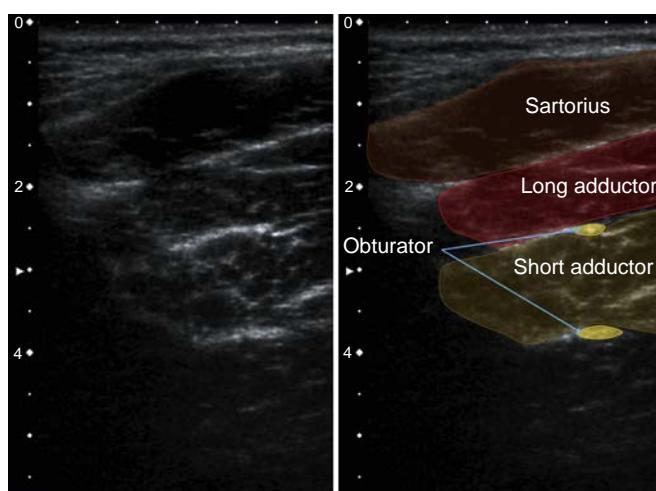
Obturator nerve block, with ultrasound imaging of the anterior and medial aspect of the thigh.
